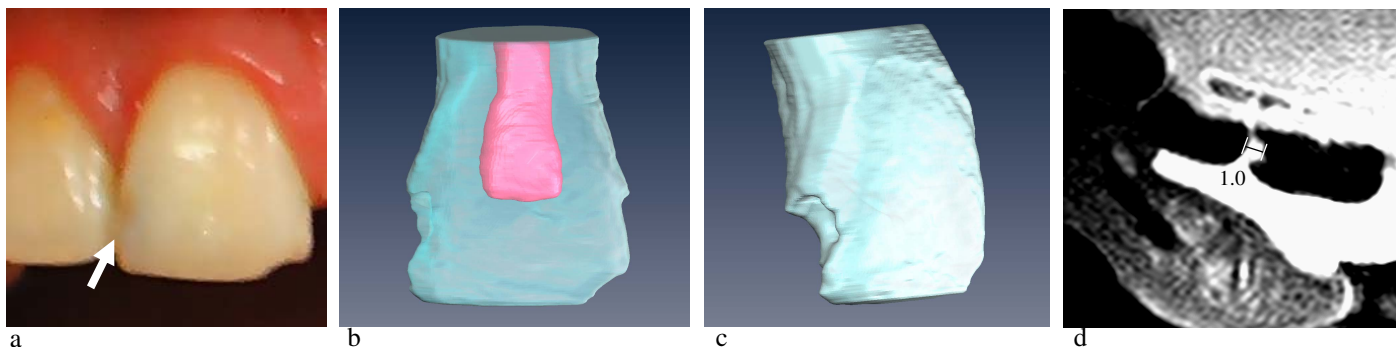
a) Photo of an upper incisor tooth with a suspected carious lesion (marked with an arrow). b) and c) 3D visualization of the tooth based on the MRI data set. d) cross-sectional view from the MRI data set.
